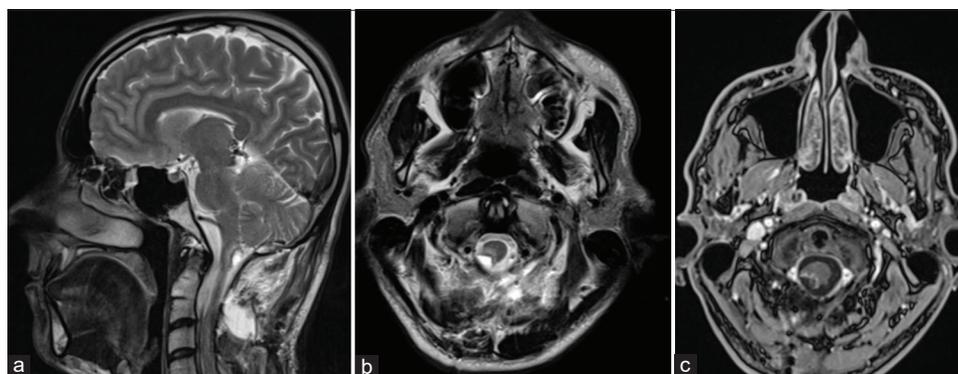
Postoperative MRI. (a) T2-weighted image, sagittal plane. Postoperative cavity and perifocal edema of the medulla and spinal cord. Subcutaneous postoperative edema of the soft tissues. (b) T2-weighted image, axial plane. The mass was resected, the same postsurgical changes. (c) Contrast enhancement axial T1. A small amount of contrast enhancement presents in the surgical field.
